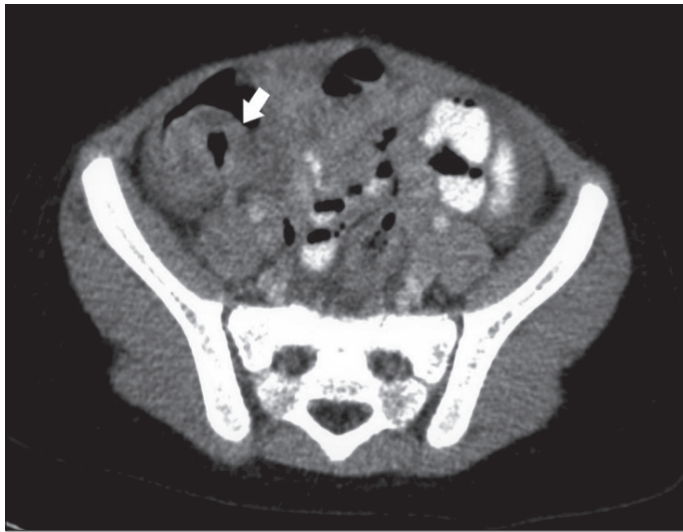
Contrast-enhanced abdominal CT of the pelvis in the axial plane.
